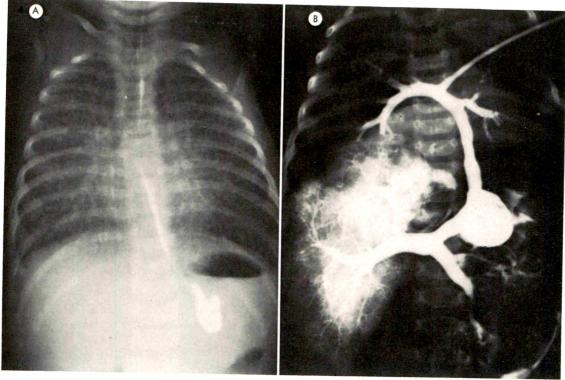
Female with total anomalous pulmonary venous return into the portal system. (A) Posteroanterior chest roentgenogram shows irregular linear and reticular densities distributed uniformly throughout the lungs with the probable presence of B-lines at the right base. (B) Postmortem injection shows drainage of pulmonary veins into the sinus venosus. Comment. This case suggests that the pulmonary shadows seen in patients with anomalous pulmonary venous return with obstruction represent interstitial pulmonary edema secondary to the elevation of postcapillary pulmonary resistance. This may develop acutely with the commencement of pulmonary blood flow at birth but can progress to a subacute or chronic state. Although dyspneic, these patients usually do not show physical findings in the chest.
